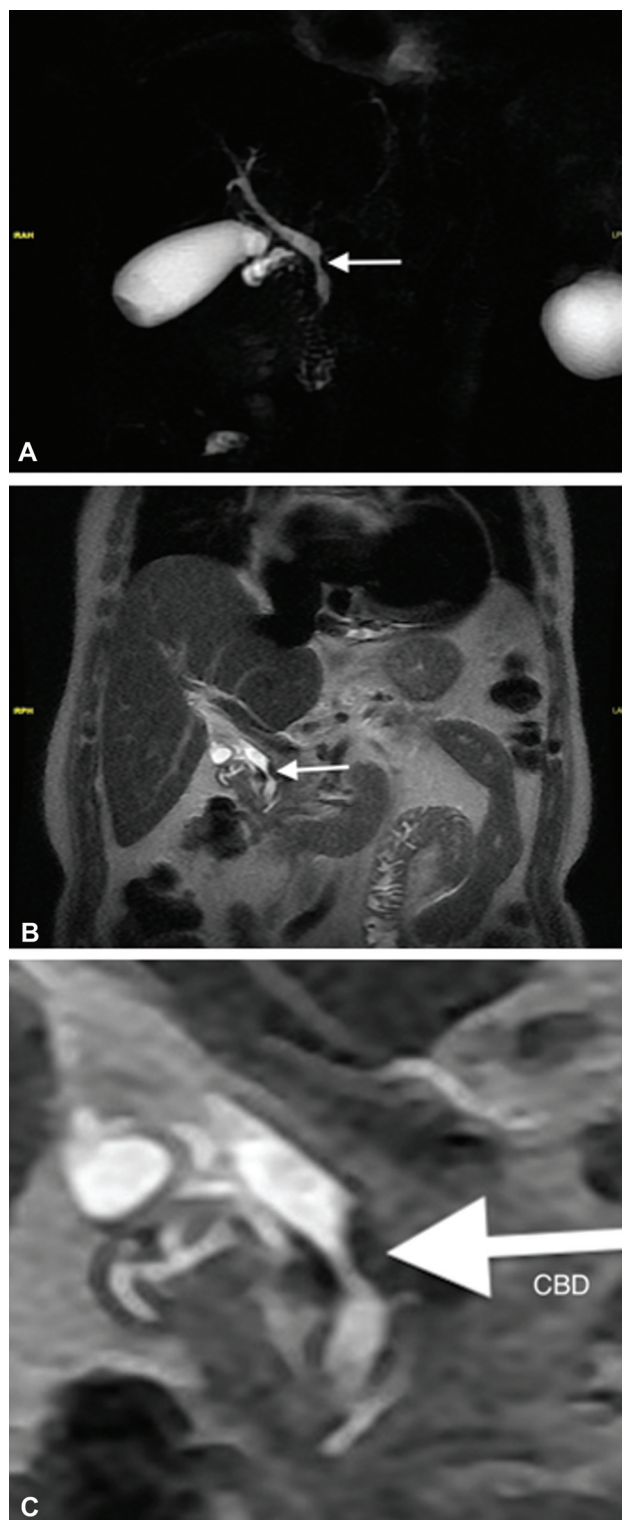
Coronal thick-slab magnetic cholangiopancreatography image (A) with standard (B) and zoomed-in (C) T2-weighted images showing band-like impingement (arrow) of the distal common bile duct and resultant mild upstream dilation.
